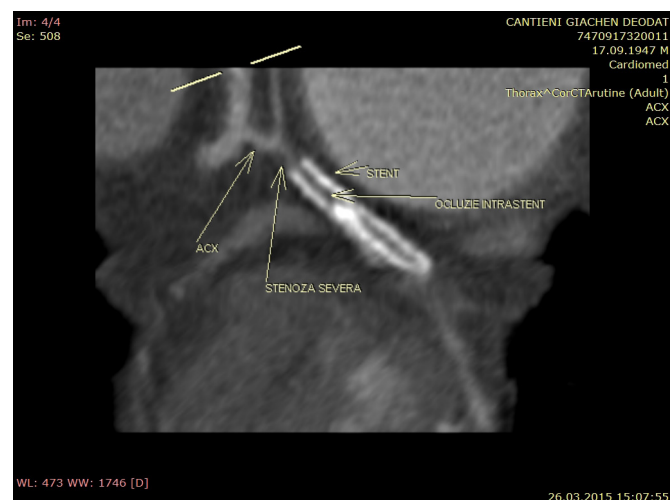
Angio CT revealing occlusion of the coronary stent
